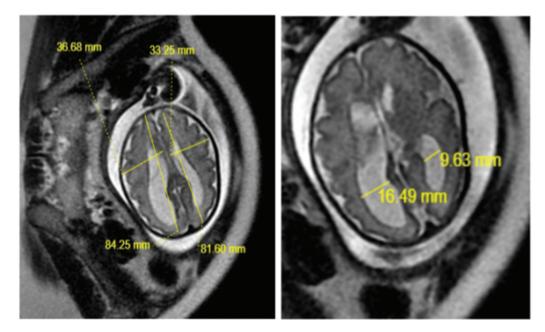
Magnetic resonance imagings measuring asymmetric cerebral hemispheres.
